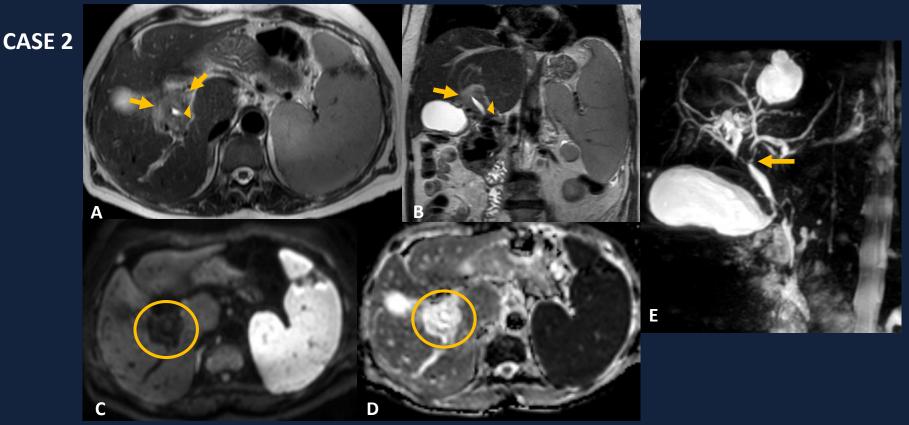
63-year old female patient with portal cavernoma. (A) Axial and (B) Coronal T2-weighted images showing a hyperintense mass-like cavernoma (arrows) with encasement of the common billiary duct (arrowhead). (C) DWI b1000 images reveal a hypointense tumor-like cavernoma (circle) that shows no restriction on ADC map (D) (circle).
